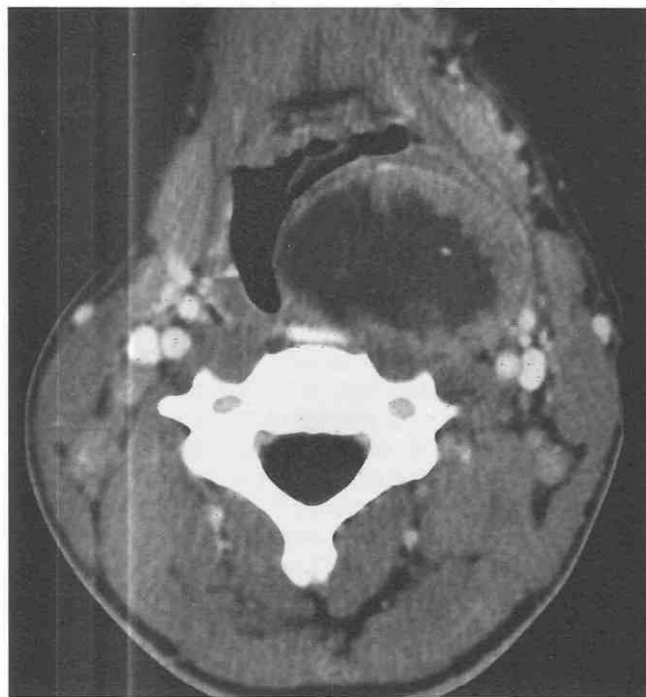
Synovial sarcoma. Axial postcontrast CT scan demonstrates a large, well-defined parapharyngeal mass with extension into the hypopharynx. The mass has an irregular wall, a necrotic center, and no evidence of significant enhancement.
